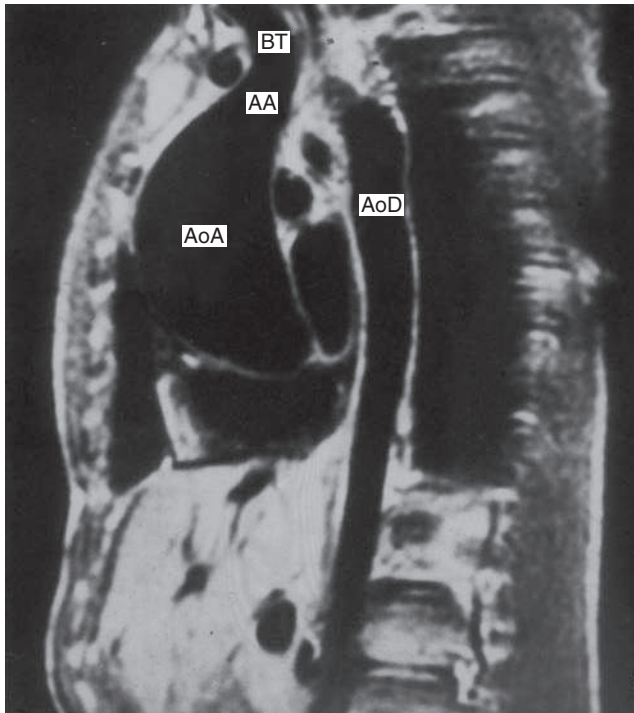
Magnetic resonance image of a young adult after coarctation repair showing a massive aneurysm of the ascending aorta. AA, Aortic arch; AoA, ascending aorta; AoD, descending aorta; BT, brachiocephalic trunk.
